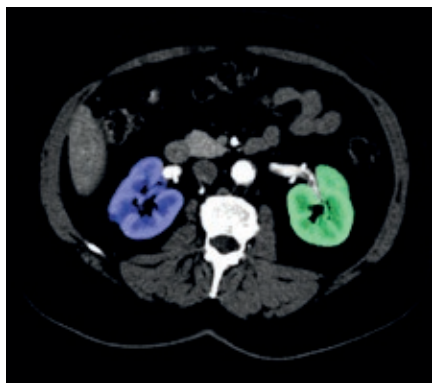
Mass determination on CT slices of kidney in radiopeptide therapy
